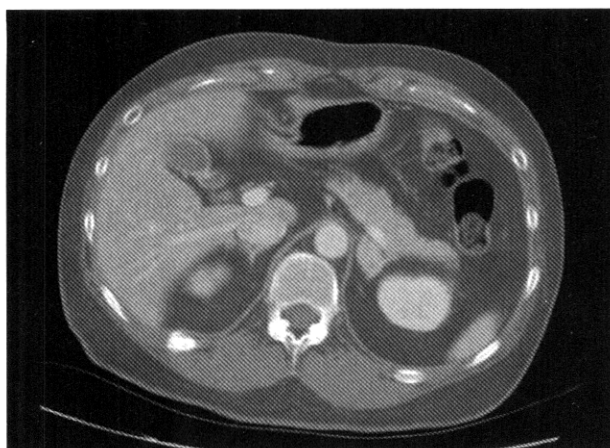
Adrenal CT shows 2.3×1.7 cm sized well defined homogenous mass in the left adrenal gland.
